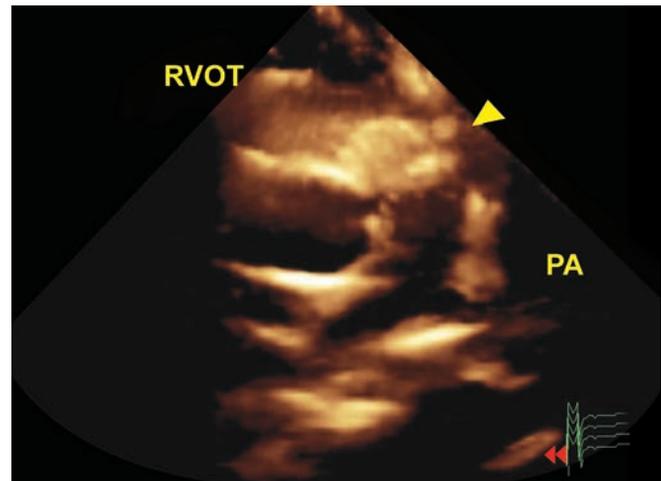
The RV mass (arrowhead) extending through RV outflow tract into main pulmonary artery in 3D parasternal short axis view.
